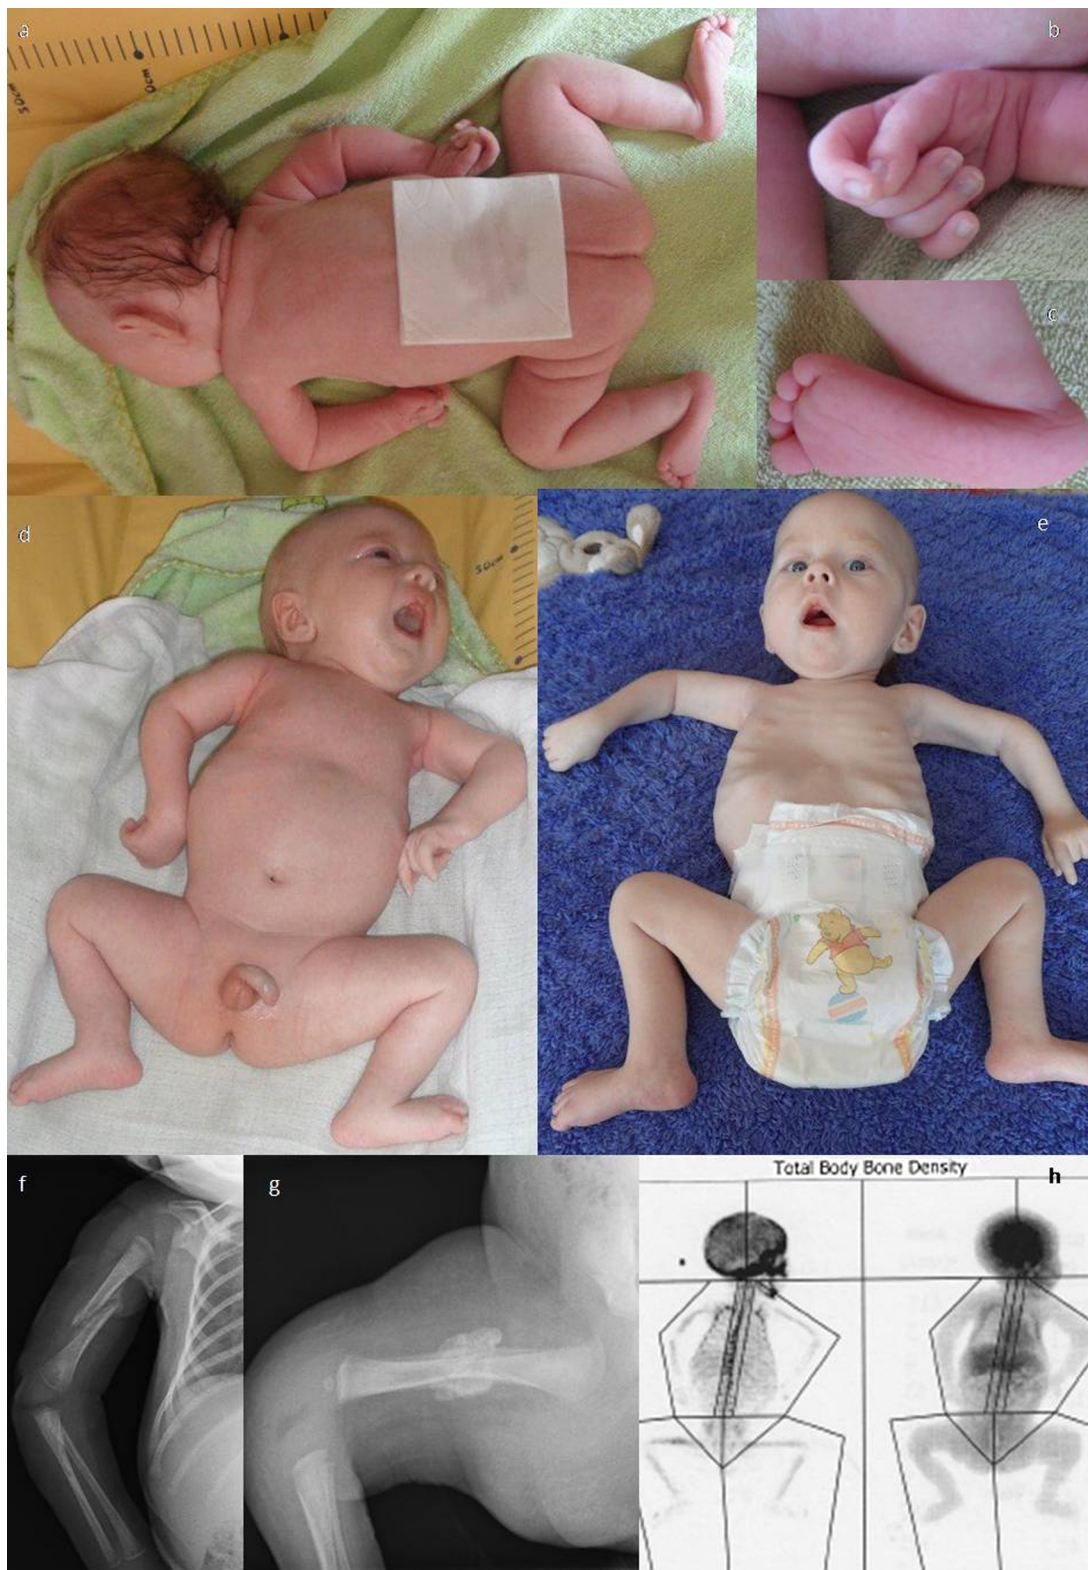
(a–c) The patient after birth. Flexion contractures in hips, knees, ankles, shoulders, elbows, wrists and fingers are observed. Note contractures of internal rotators of the shoulder giving a “jug-handle” posture of arms, typical for the very severe form of *SMN1*-dependent SMA. (d) The patient at the age of six weeks. Contractures and weak spontaneous movements are still present. Testes are undescended. (e) The patient at the age of 5 months. Note good eye-contact but poor facial expression with tent-shaped mouth. Movements are restricted to proximal parts of the upper limbs. Contractures are milder but still present. Fingers are flexed, with difficulty opening the hands. The chest is wide, non typical for severe *SMN1*-dependent SMA (f) X-ray showing the right humeral fracture. (g) Healing fracture of the right femur (19th day of life). (h) Densitometry; Infant Programme, TBLH (total body less head) 0.273 g/cm².
